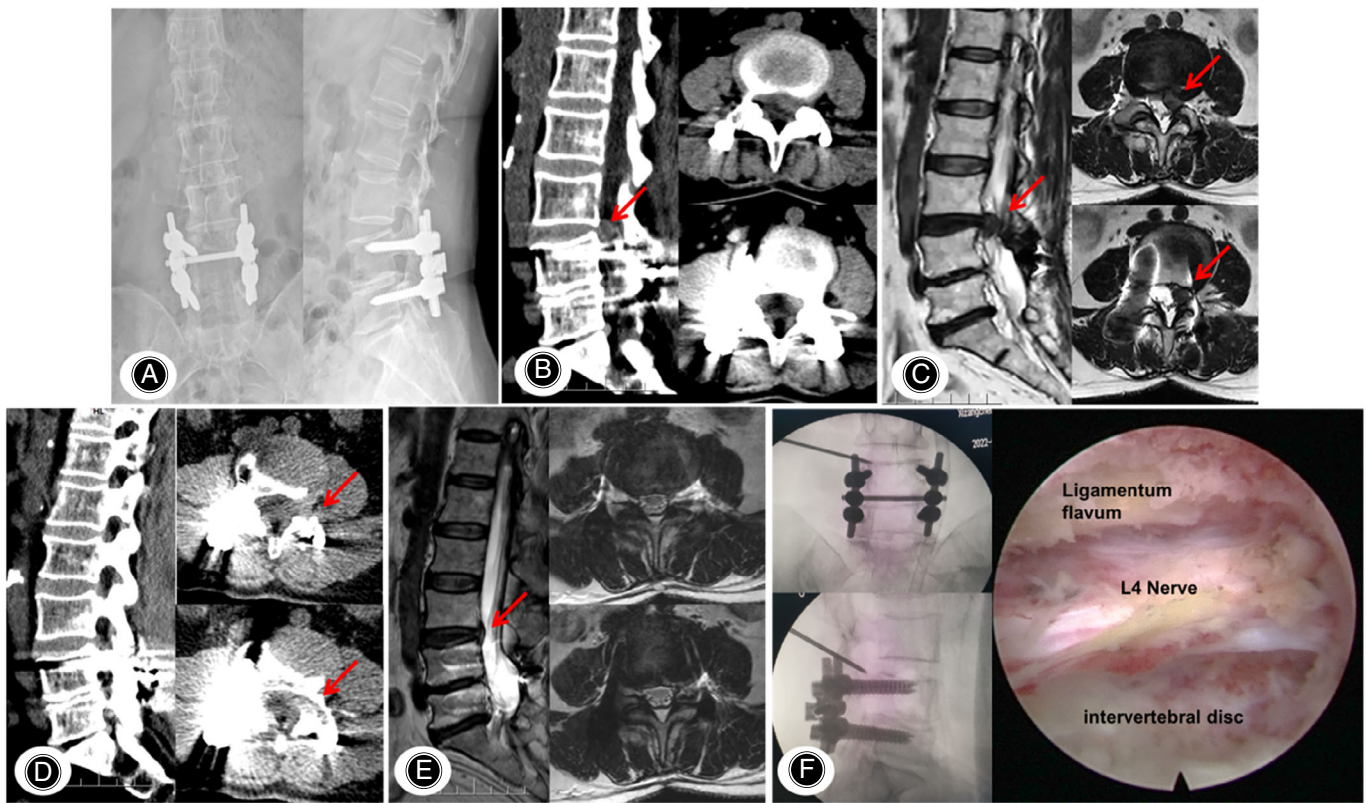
A 65-year-old woman with symptomatic ASD who underwent PELD. (A) Preoperative anterior and lateral X-rays showed that the lumbar 4/5 had previously undergone PLIF surgery; (B, C) Preoperative CT and MRI showed herniation of the intervertebral disc in the left of adjacent lumbar 3/4 segment (red arrow); (D, E) Postoperative CT and MRI showed that the herniated intervertebral disc on the left side of the lumbar 3/4 had been removed (red arrow); (F) Intraoperative fluoroscopy showing the placement of the guide needle and L4 nerve root after decompression
